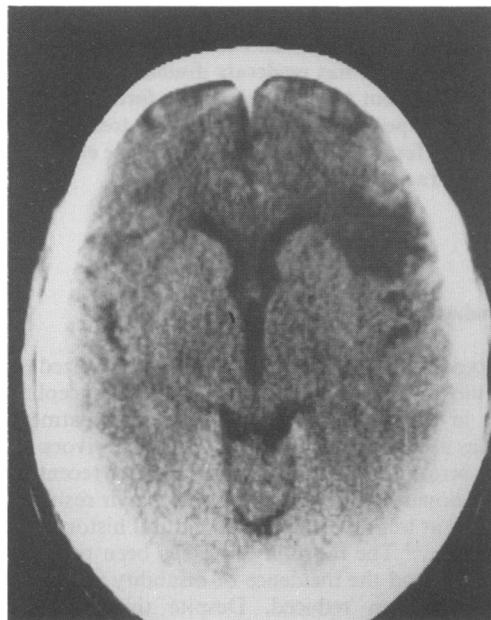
CT head scan for case 1 on admission showing right temporal low attenuation lesion.
